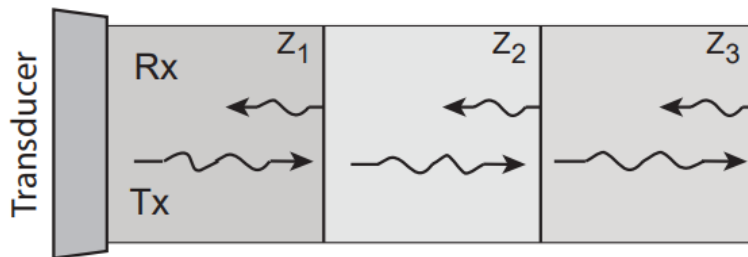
The concept of pulse-echo ultrasound imaging where the transmitted pulse, Tx , encounters different types of tissue with impedances denoted as Z_1 , Z_2 and Z_3 . The received signal at the transducer is denoted as Rx [19].
